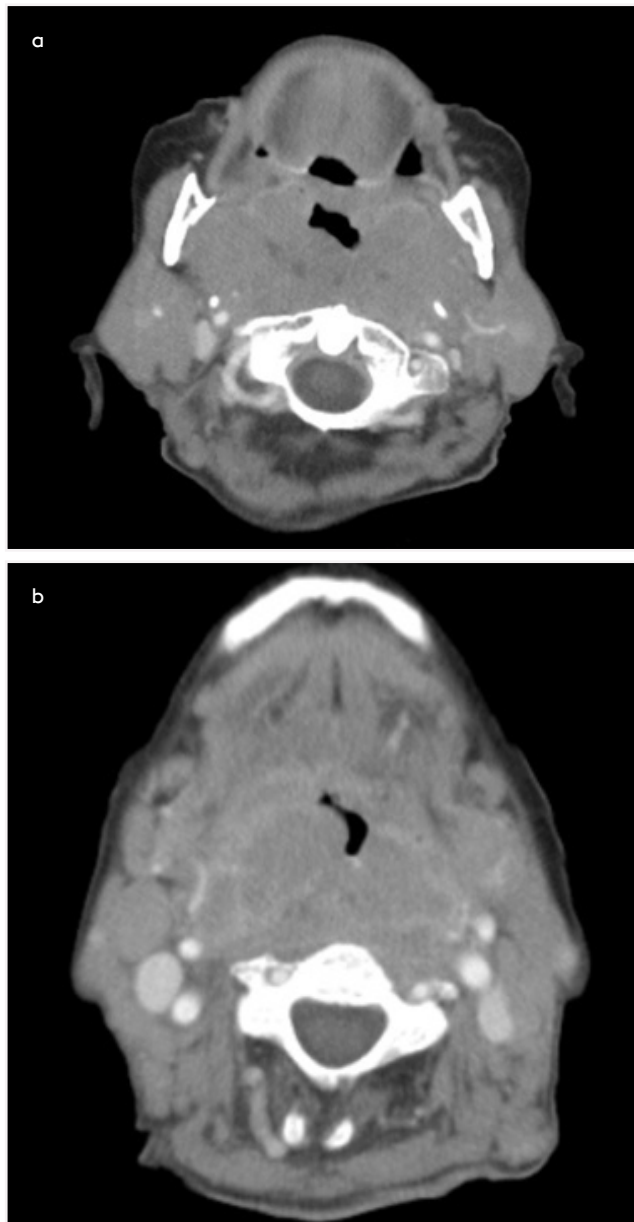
a, b. A 87-year-old female patient with secondary EHNL (NHL, Diffuse large B-cell lymphoma, stage II E) in Waldeyer's ring, received chemotherapy and exitus at 4 months. Axial contrast-enhanced CT images (a and b) show ill-defined, irregular shaped, moderately heterogeneous enhanced mass affected bilateral tonsils, nasopharynx and base of tongue.
